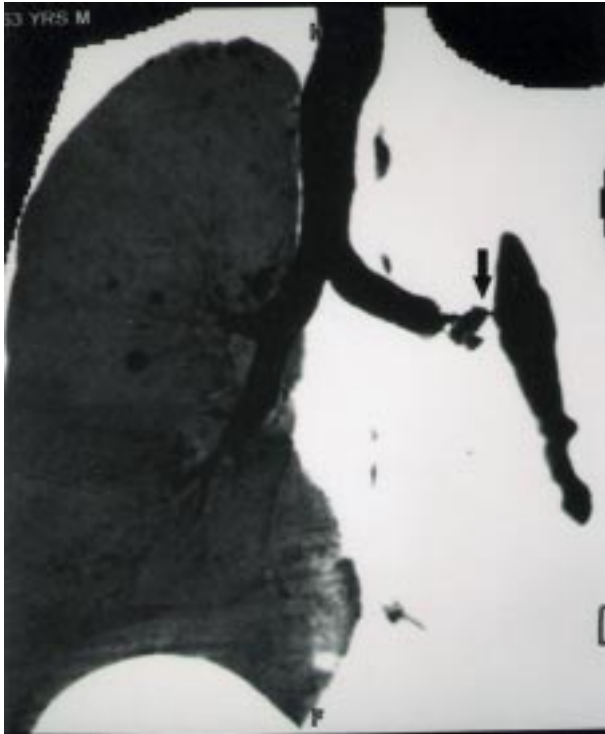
Frontal view of 3-D CT scan minimum-intensity-projection reconstruction showing the fistulous communication (arrow).
